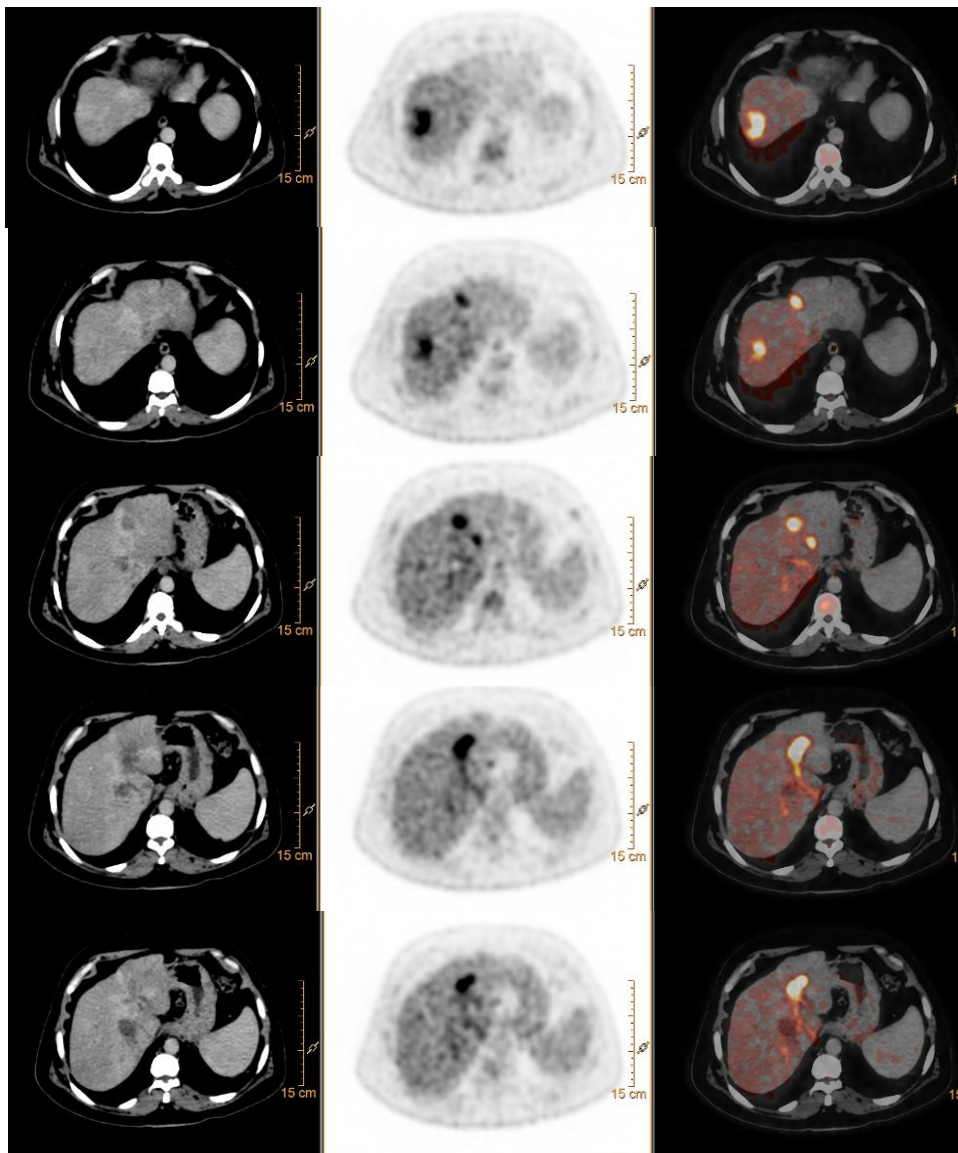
showing a 57 years old male patient presented with surgically resected HCC with elevated alpha-fetoprotein, the images show recurrent metabolically overactive mass lesion at the caudate lobe with partial encasement of the IVC, yet no evidence of direct infiltration. The mass shows increased FDG uptake with SUVmax of 15. Few hypermetabolic peripancreatic and celiac metastatic lymphadenopathy matted together to form sizeable mass showing increased FDG uptake with SUVmax of 14.
